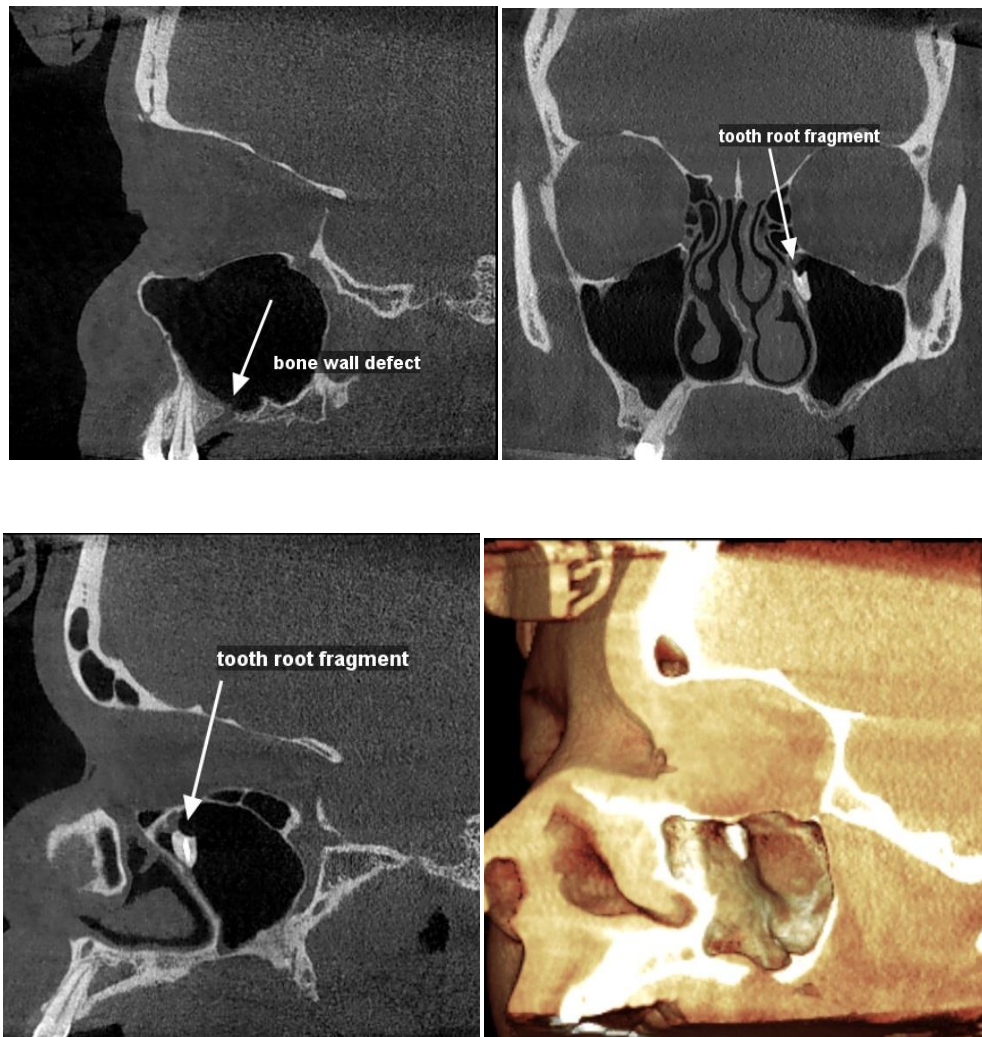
Patient S. is 46 years old. A fragment of a tooth root located in the upper parts of the maxillary sinus is noted on the CBCT of the paranasal sinuses. Bone defect of the alveolar regurgitant of the upper jaw in the location of the secondary dentition of the molars.
